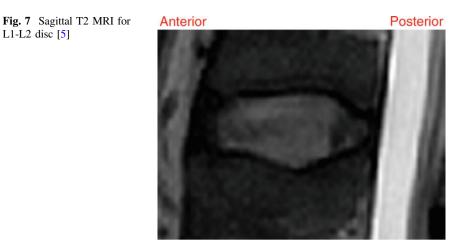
Sagittal T1 MRI for L1-L2 disc [5]
